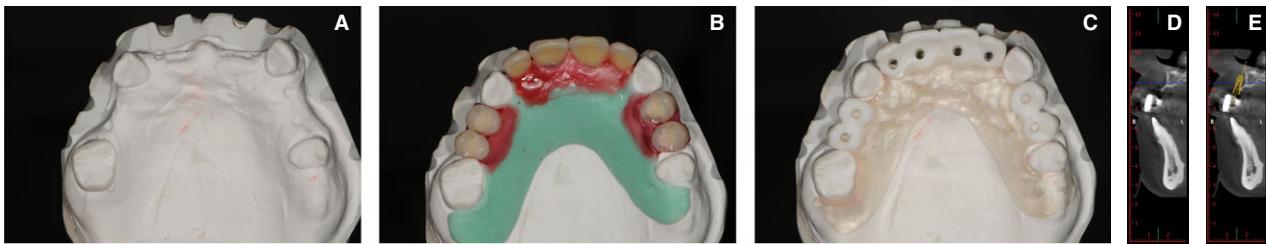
(The same patient as shown in Fig. 3.) A radio-opaque diagnostic template is created from the wax-up, which also served as a mock-up (A–C). Cone-beam computerized tomography is performed with the diagnostic template *in situ*, allowing precise quantification of the horizontal
